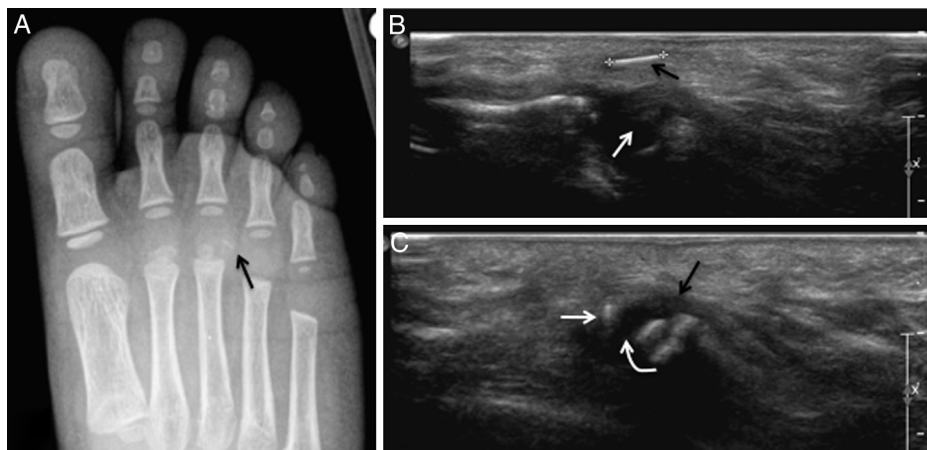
(A) Oblique radiograph of the right foot in a 2-year-old patient showing 2 perpendicular, faint, linear, dense structures in the region of the third metatarsal head (arrow). (B) Sagittal ultrasound image at the plantar foot revealing a 5-mm linear structure consistent with a foreign body (black arrow) in the subcutaneous tissues over the third metatarsal head (white arrow). (C) Sagittal ultrasound image showing 2-mm linear object (straight white arrow) embedded in a tendon (black arrow) overlying the third metatarsal head (curved white arrow).
